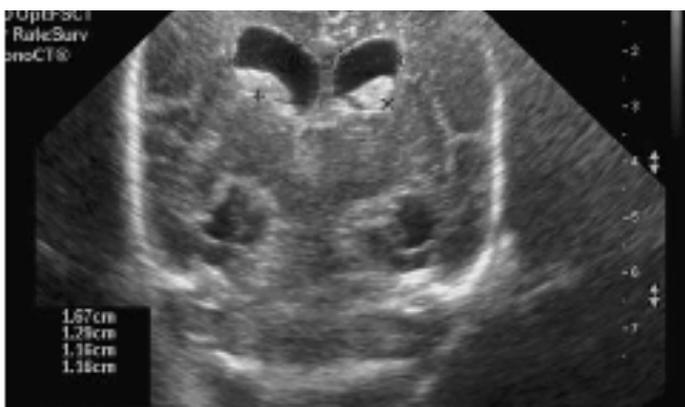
Cerebral ultrasonography of patient 2 shows bilateral intraventricular bleeding with extravasation to the third and fourth ventricle and ventricular dilatation
